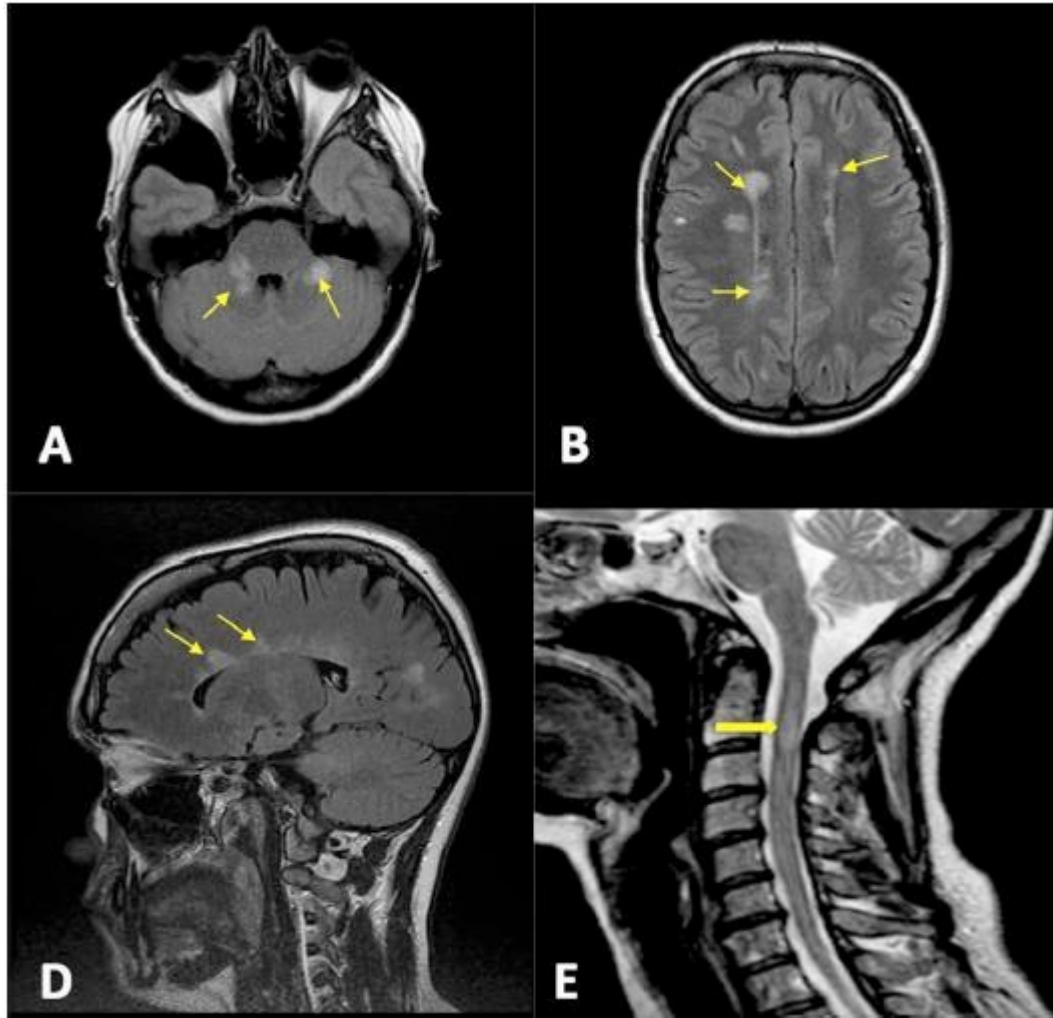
Examples of T2-weighted lesions in a person with RRMS that fulfill criteria for dissemination in space. A. Axial fluid-attenuated inversion recovery (FLAIR) brain scan showing infra-tentorial lesions. B. Axial FLAIR brain scan demonstrating periventricular lesions. C. Axial FLAIR brain scan demonstrating a juxtacortical lesion. D. Sagittal FLAIR brain scan demonstrating callosal lesions ('Dawson's fingers'). E. Sagittal T2-weighted scan of the cervical spinal cord demonstrating a focal lesion. Reproduced from ref. (Kearney, Cahalane et al. 2018).
